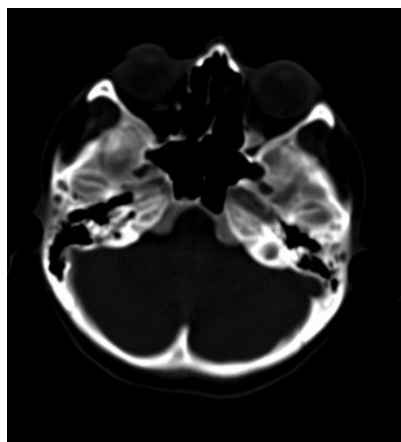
Transverse computed tomography image at the level of carotid canal demonstrates the absence of right carotid canal.
